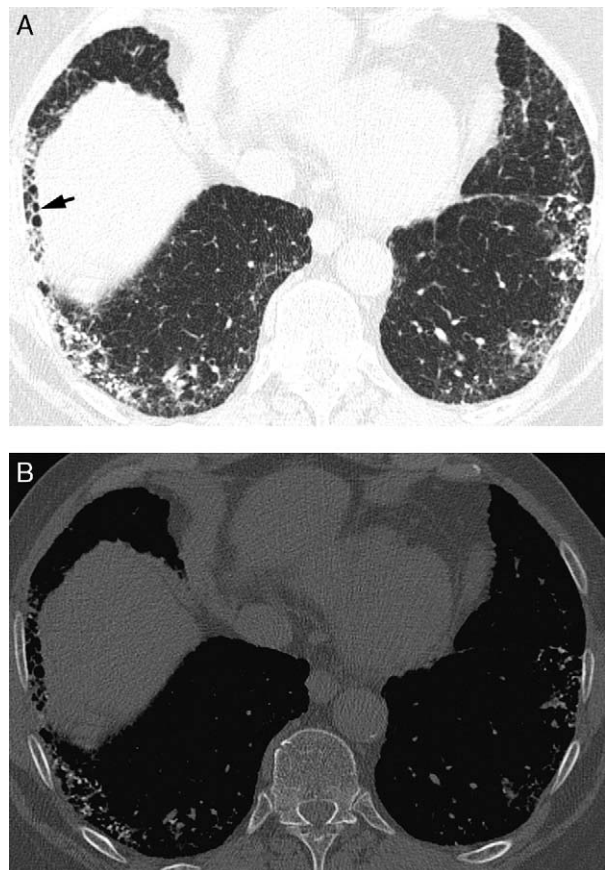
Pulmonary ossification in idiopathic pulmonary fibrosis in an 80-year-old man. A, HRCT image at the level of the right hemidiaphragm photographed at lung windows shows peripheral reticulation, mild honeycombing (arrow), and several small nodular opacities. B, HRCT image photographed at soft tissue windows shows calcified small nodules within the areas of reticulation consistent with pulmonary ossification.
